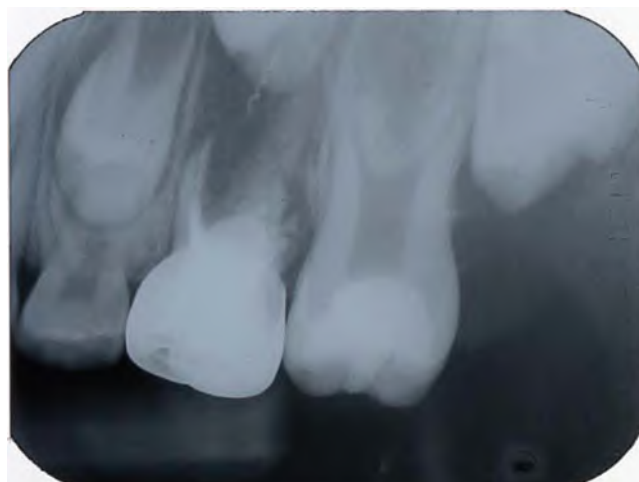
Follow-up periapical radiograph of an unsuccessful endodontic treatment in the primary maxillary left second molar. Note the separated segment of lentulo spiral associated with a large periapical radiolucency coronally to the permanent successor that shows delayed eruption. (Courtesy of Dr. Moti Moskovitz, Jerusalem, Israel.)
